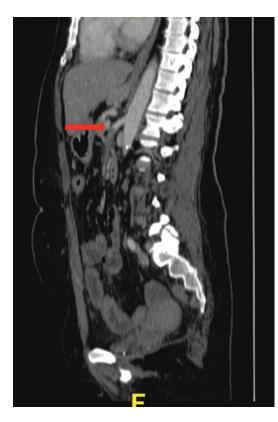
Sagittal CTA reconstruction of cardiac embolus in mid-SMA (red arrow) in patient with AMI
